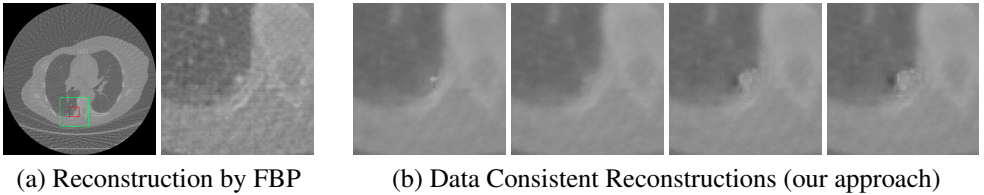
Reconstruction ambiguity. Reconstruction methods such as Filtered Back Projection (FBP) [14] typically yield only one data-consistent output (a). However, there are many possible reconstructions (b) that are consistent with the data term, but differ in their pathological categorization, i.e. with respect to their malignancy. This ambiguity, which increases when using sparse-view CT, is demonstrated here for  $p = 50$  projection angles.
